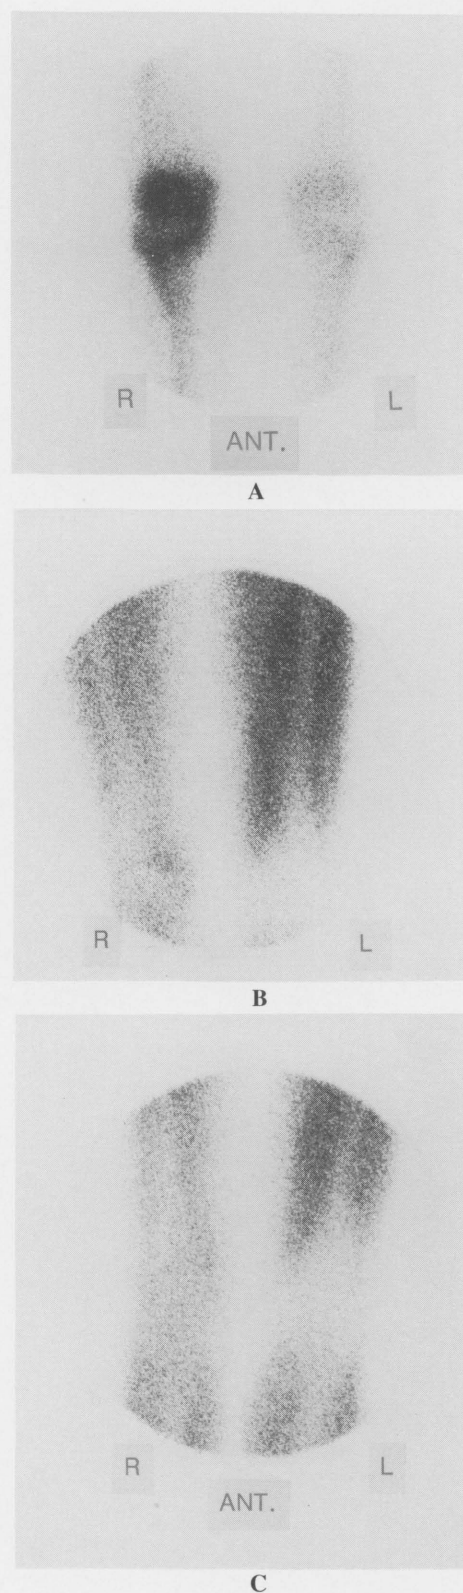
Female, 34 yr, with pigmented villonodular synovitis of the right knee. Bone scintigram with Tc-99m HMDP (A) shows abnormal accumulation in the right knee. Early scintigram (B) shows a spotty uptake of Tl-201 in the lower right knee. It is rather obscure on the delayed scintigram (C). T/M ratio of the early scintigram is 1.2 and 0.9 of the delayed scintigram.
